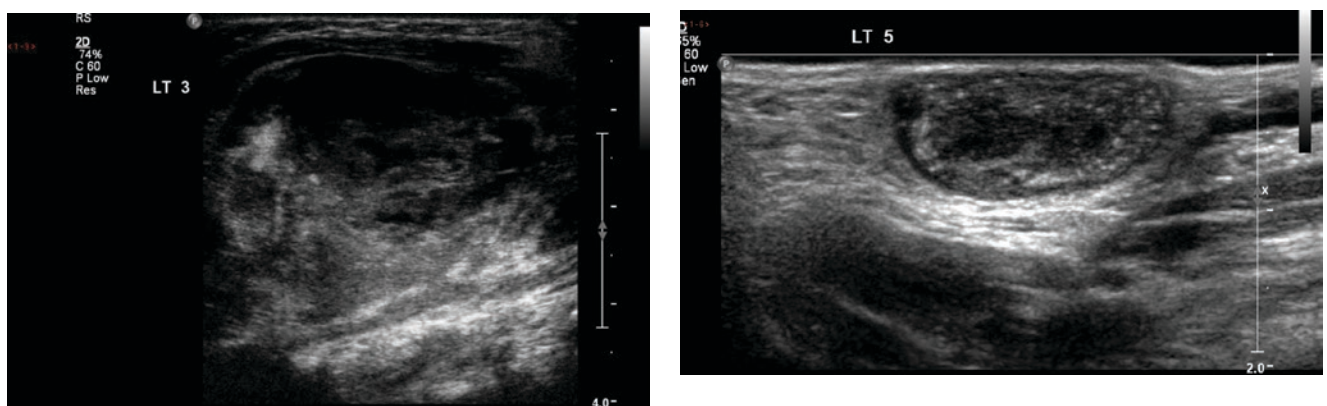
Longitudinal ultrasound image shows an established lymph node abscess with echogenic and anechoic contents
